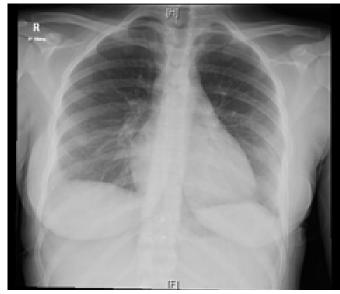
Chest X-ray on the day of admission, showing no pulmonary lesions and costo-phrenic sinuses blunted bilaterally.
